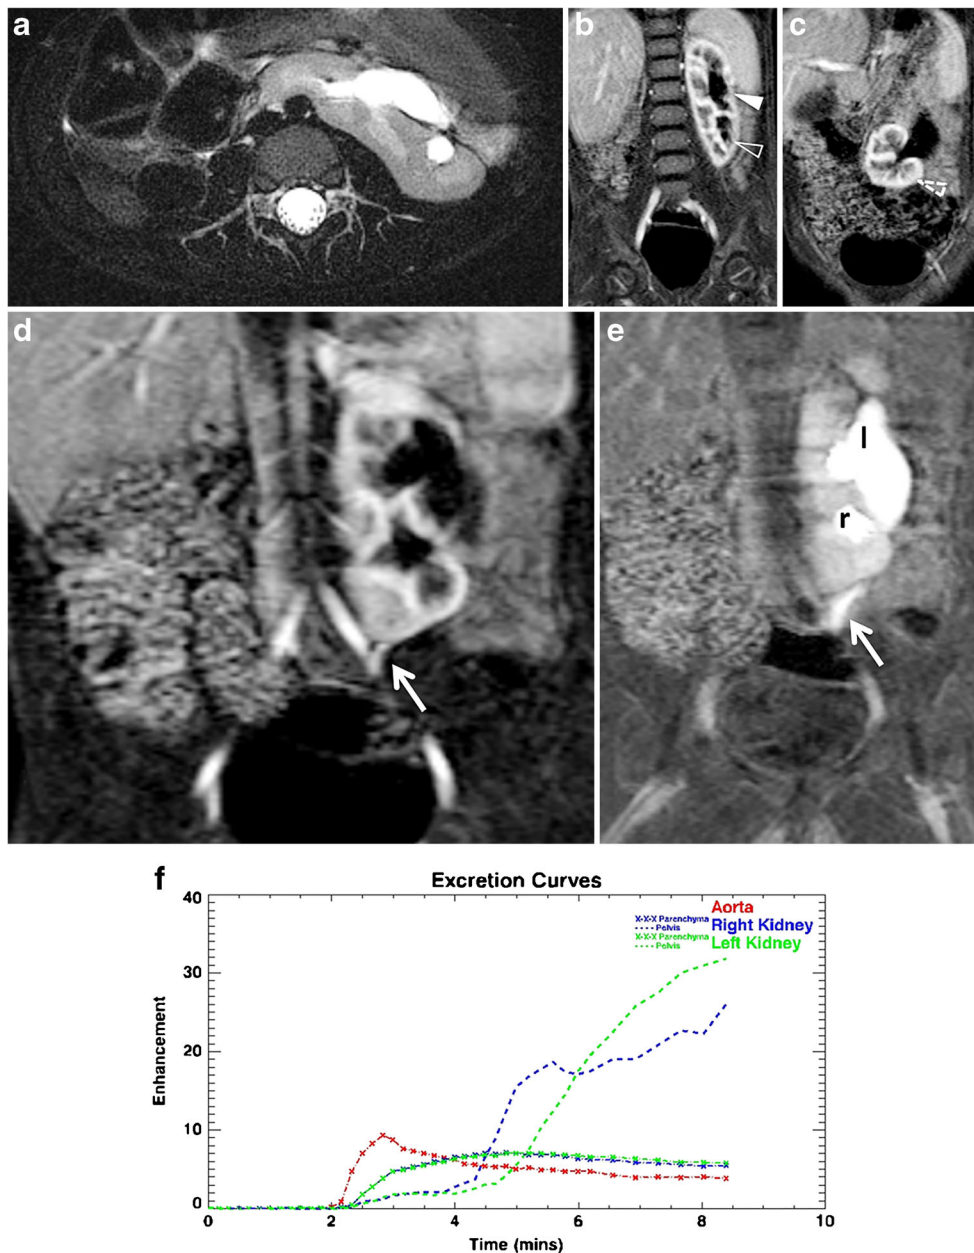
A 2-year-old girl with right to left crossed-fused superior renal ectopia and grade IV vesicoureteral reflux shown by voiding cystourethrogram. a Axial T2-weighted fat-saturated and (b, c) coronal T1-weighted fat-saturated post-contrast images show the right renal moiety has crossed the midline and its superior pole (*hollow arrowhead*) has fused with the inferior pole of the left renal moiety (*solid arrowhead*), which remains in its expected anatomical location in the left renal fossa. The lower pole of the right renal moiety extends to the midline (*dashed arrowhead*). The right renal moiety does not have a separate ureter, but communicates with the collecting system of the left renal moiety as a bifid system. d Coronal T1-weighted fat-saturated post-contrast image during the arterial phase shows an aberrant renal artery
